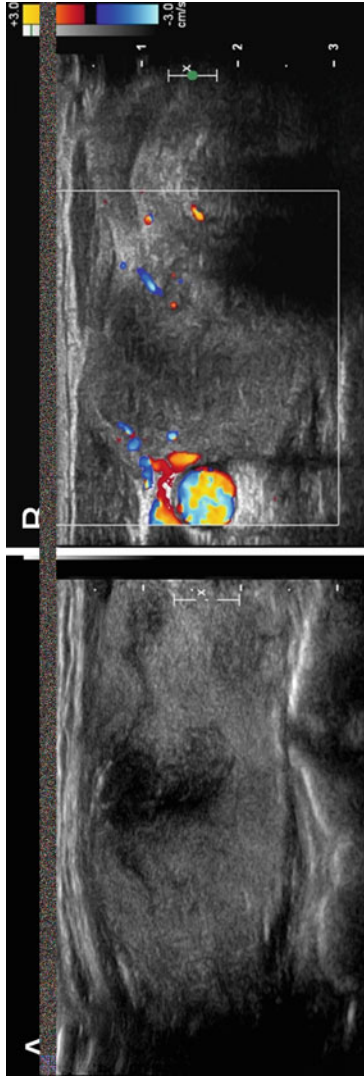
Ultrasound appearance of subacute thyroiditis demonstrating thyroid enlargement with hypoechogenicity and pseudonodular appearance (a). Using color flow Doppler, there is low vascularity (b)
